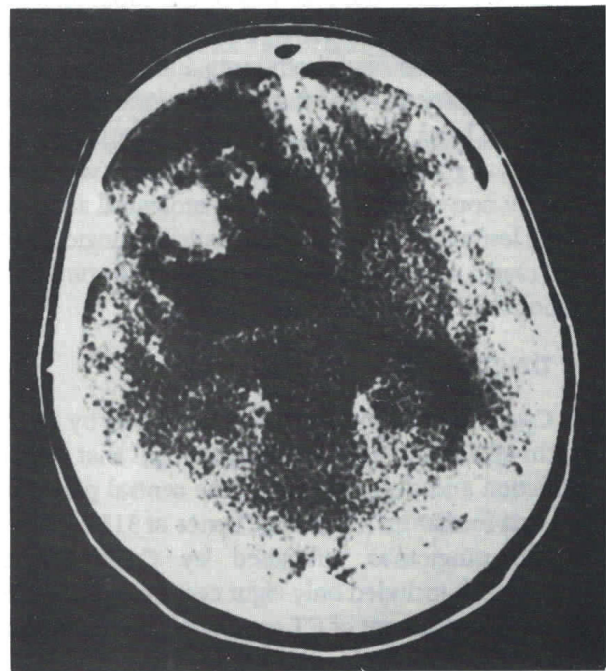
(Case 4) A frontal solid tumor with peritumoral cyst is shown on postcontrast CT scan.
